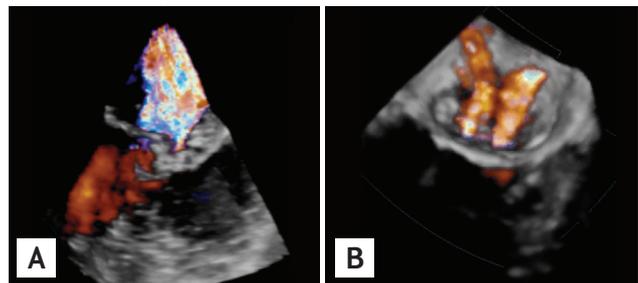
Two types (A, one continuous jet; B, two separate jets) of functional mitral regurgitation jet clearly distinguished by color Doppler 3-dimensional transesophageal echocardiography.
